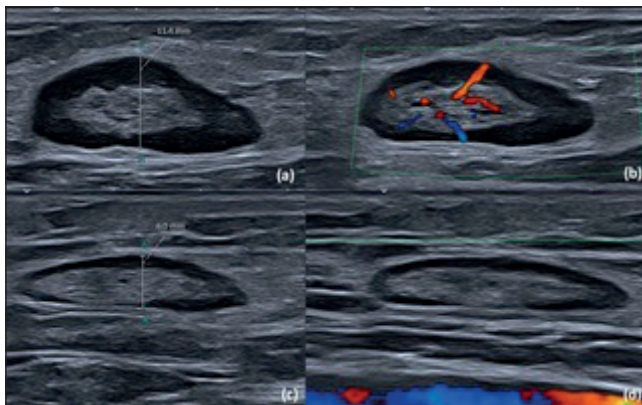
Grey scale (a) and Colour Doppler (b) ultrasound images of the right groin 10 days after the COVID vaccine demonstrated a mildly enlarged superficial femoral lymph node (vertical group) measuring 11.4 mm in short axis diameter with preserved fatty hilum and minimally increased hilar vascularity, in keeping with a reactive lymphadenitis, corresponding to clinically palpable mildly tender lump.
